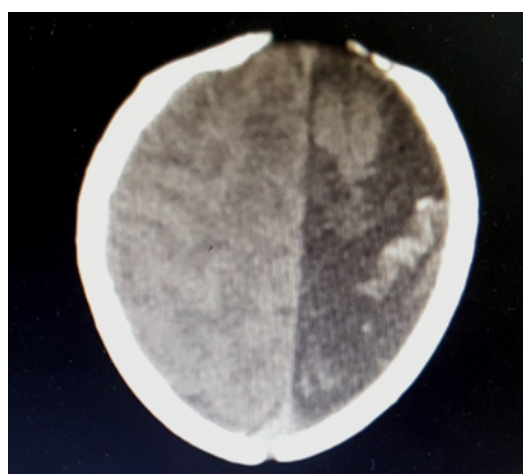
Brain computed tomography scan, old infarction and calcium deposition around the left mid-cerebral artery
